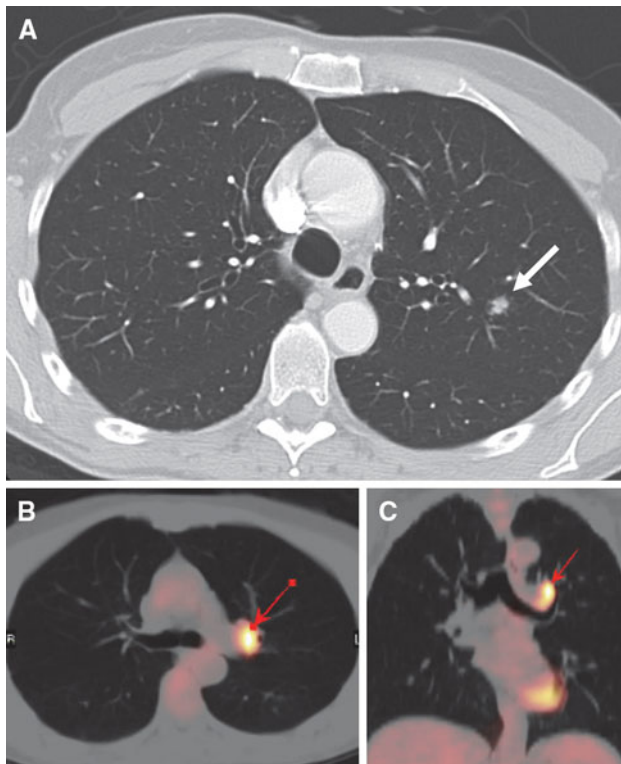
a Computed tomography of the thorax of a 54-year-old female with a round mass in the left upper lobe measuring 2.5 cm. b, c PET-CT scan shows enlarged FDG-positive ipsilateral hilar lymph nodes while the primary pulmonary tumor is FDG-negative
